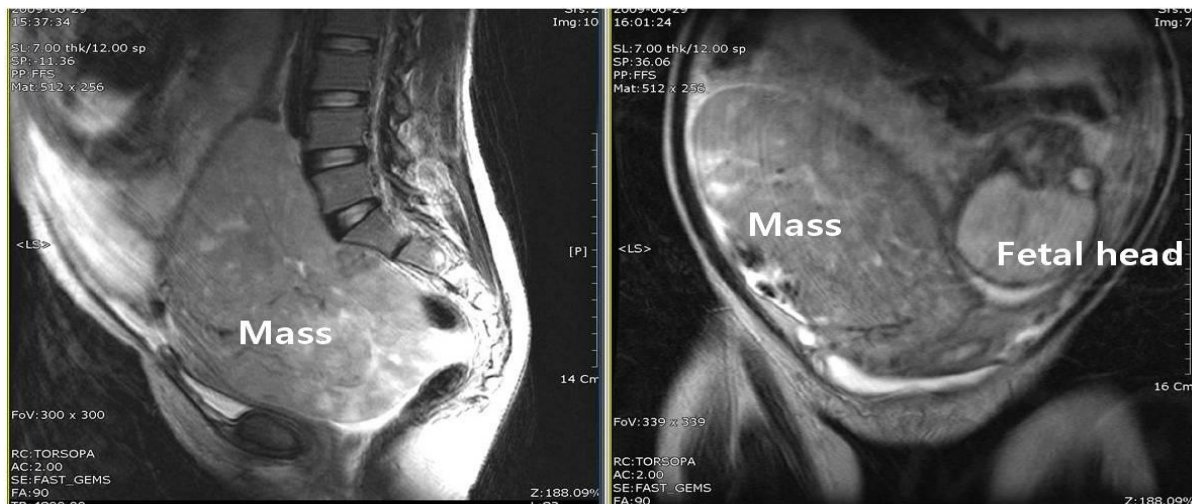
Pelvic magnetic resonance imaging without enhance was performed. The mass measured 22 cm in sized and the fetal head was also observed
